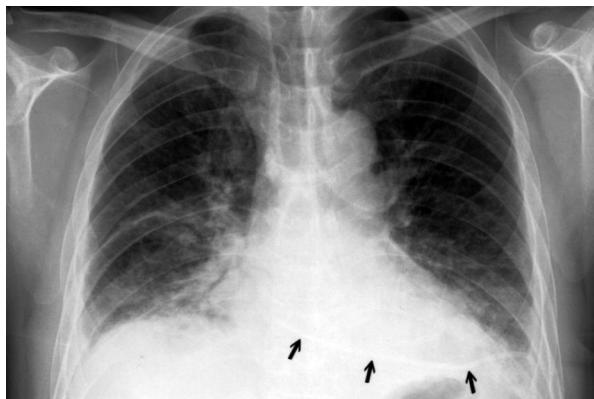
Chest radiograph before removal of the pericardial drainage catheter. Black arrows denote the indwelling pigtail catheter inserted through the posterolateral aspect of the 7th intercostal space. No evidence of air leak was found at that time. Increased infiltrates in the bilateral lower lung fields indicated pneumonia.
